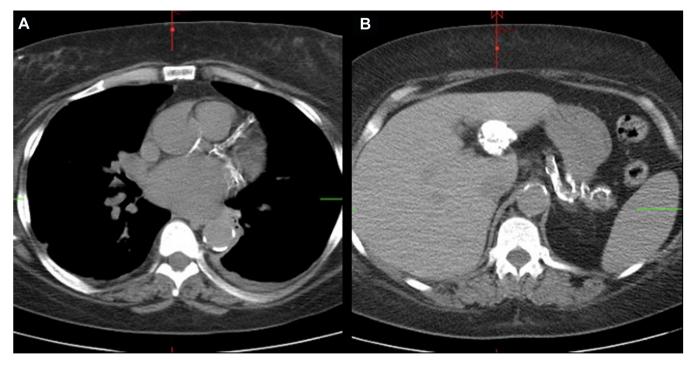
Computed tomography transverse view of the abdomen showing atherosclerotic disease involving the aorta and multivessel coronary arterial disease (A) and calcified hepatic lobe and partial pancreas (B).
